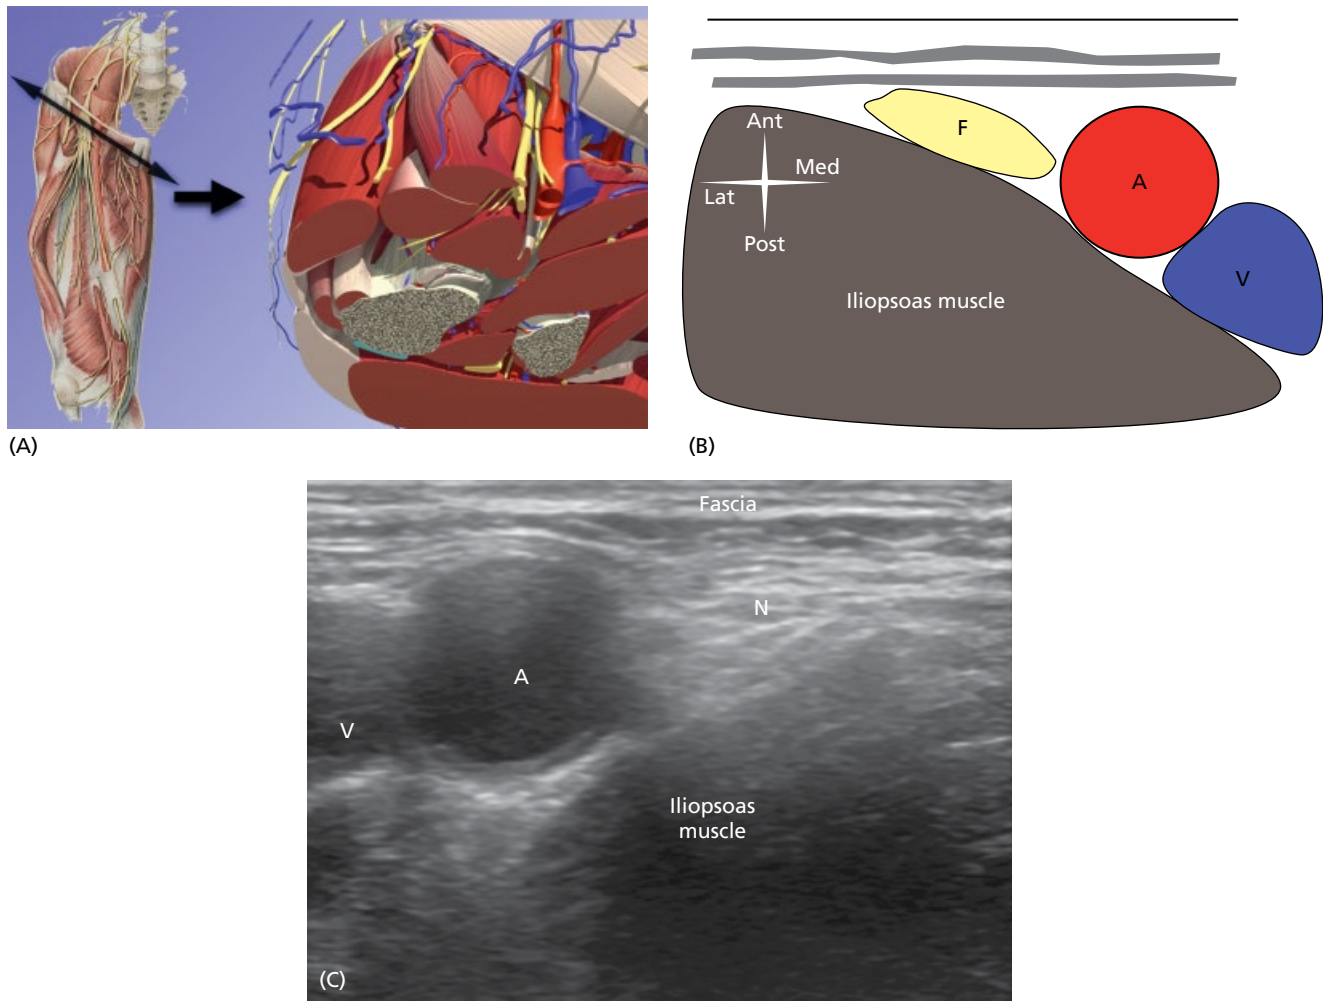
The femoral region. (A) Anatomy. (B) Ultrasound imaging. With the probe placed perpendicular to the nerve axis (i.e. coronal oblique) at the level of and parallel to the inguinal crease, the nerve appears lateral to the large, circular, and anechoic femoral artery. (C) Ultrasound image. F, femoral nerve; A, femoral artery; V, femoral vein. See text for further details.
